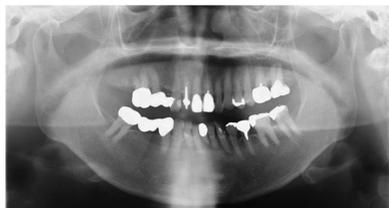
Panoramic X-ray at the first examination. No dental focus of infection that could cause pain was found in the mandible.
